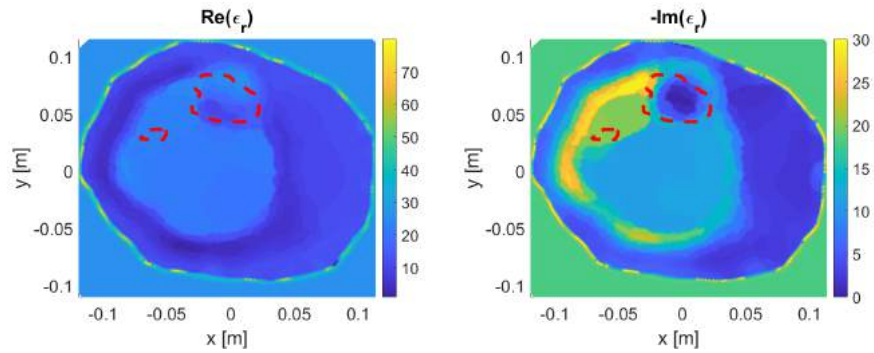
Changing location of antennas to enhance MRI model 2 reconstruction.
